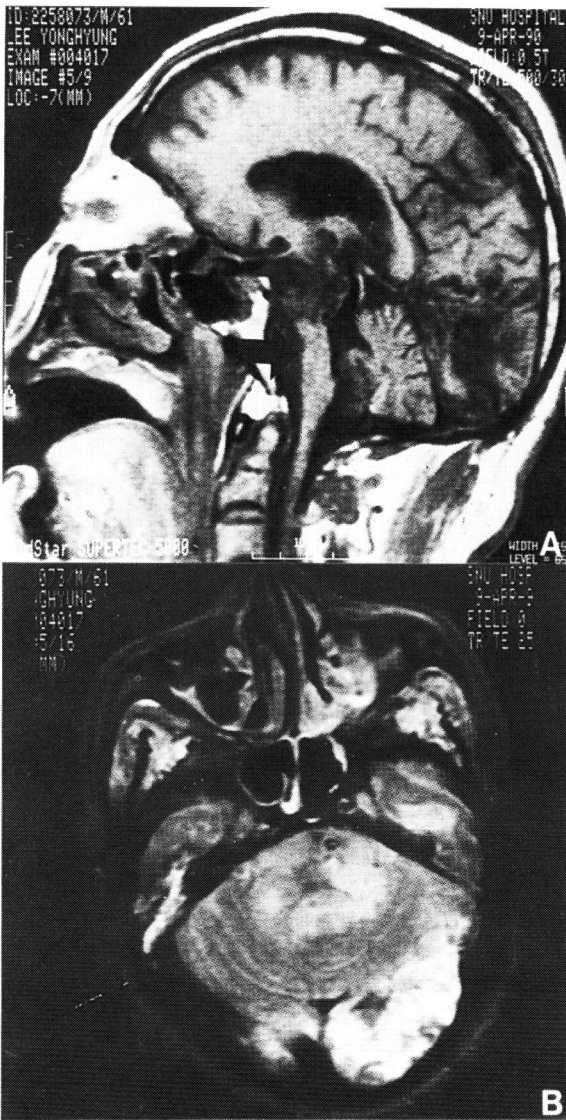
Brain MR imaging of the patient(A, B, C, and D)
